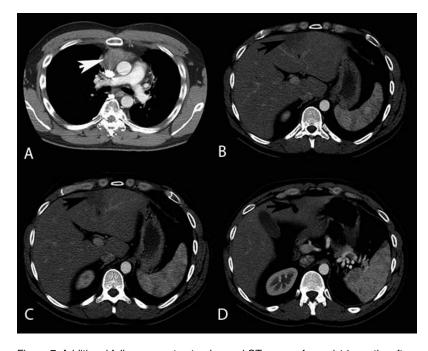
Additional followup, contrast-enhanced CT was performed 14 months after the initial CT. These axial images were obtained in early arterial contrast phase following the administration of 80mL of Omnipaque-350 intravenous contrast via the right upper extremity. During this time, there was interval decrease in the size of the mediastinal mass (white arrow, A). A persistent region of parenchymal hypoattenuation was again seen involving segment IV of the left lobe of the liver (B-D). Stability of this hepatic finding over time lends support to the hypothesis that the increased PET activity associated with this lesion was nonmalignant in etiology.
